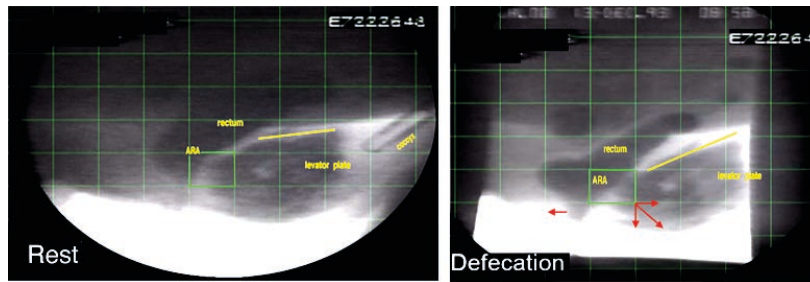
X-ray defecating procto-myogram
